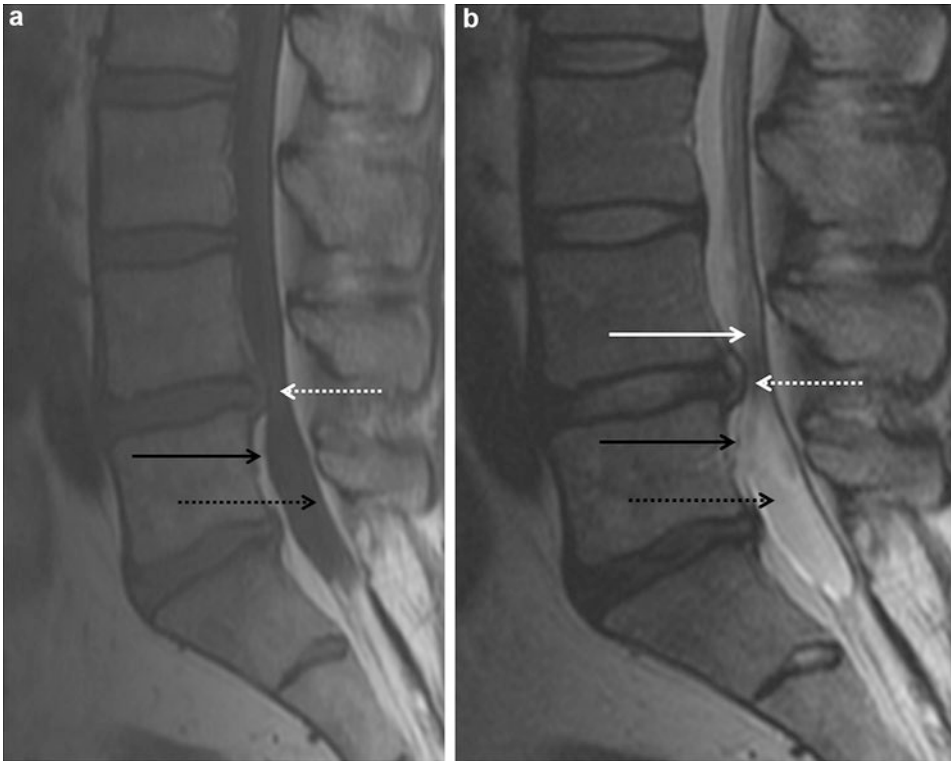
(a) Sagittal T1-weighted MR image of the lower lumbar spine demonstrates the utility of T1-weighting in differentiating epidural fat (*solid black arrow*), which is hyperintense in signal intensity, versus cerebrospinal fluid in the thecal sac (*dashed black arrow*) which is hypointense in signal intensity. Note the L4–L5 disc bulge which effaces the epidural fat and makes a ventral impression upon the thecal sac resulting in focal spinal canal stenosis at this level (*dashed white arrow*). The cauda equina nerve roots are not well seen because they are of similar signal intensity relative to the CSF due to suboptimal contrast resolution.
